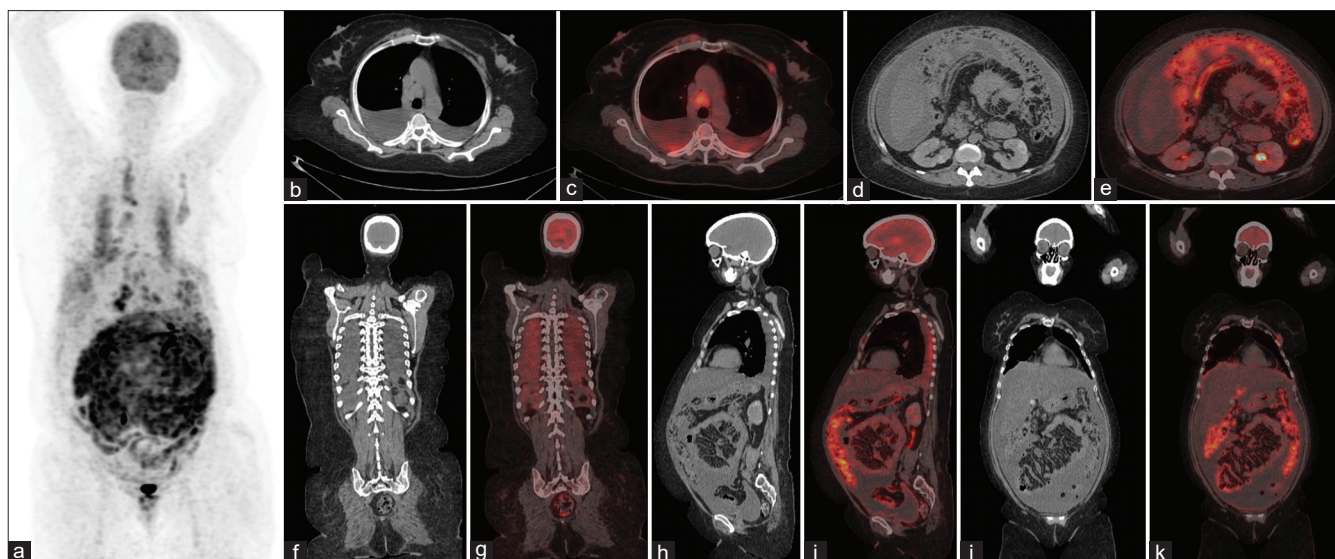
For staging. A 50-year-old female presented with complaints of abdominal distension. Serum CA 125 levels were 4755 U/ml, and omental biopsy showed features of metastatic adenocarcinoma, suspicious of carcinoma ovary. PET-CT for initial baseline staging showed lymph node metastasis and extra-abdominal spread. MIP images (a) shows diffusely increased tracer uptake in the abdominal cavity and also the bilateral hemithorax. Transaxial CT (b and d) and fused PET-CT (c and e) images showed bilateral pleural effusion, enlarged mediastinal lymph nodes, moderate-to-gross, ascites and diffuse omental caking with increased FDG uptake. Sagittal (h and i) and coronal (f, g, j, and k) CT and fused PET-CT images demonstrates bilateral pleural effusion, gross abdominal-pelvic ascites, and FDG avid omental caking. The patient was diagnosed as ovarian carcinoma Stage IVB and started on neoadjuvant chemotherapy. PET/CT: Positron emission tomography/computed tomography, FDG: Fluorodeoxyglucose
